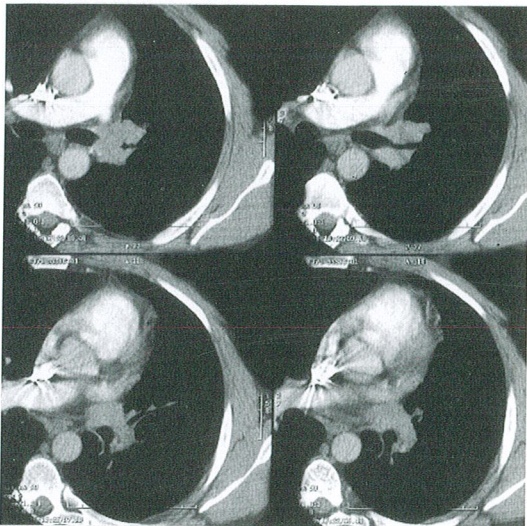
Computed tomographic scans of the second patient.
